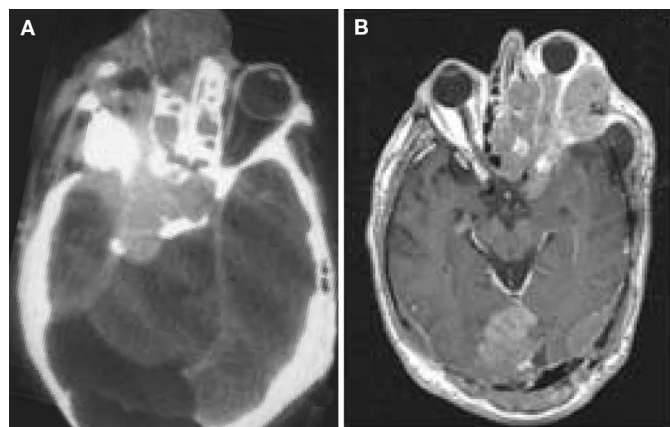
A, axial computed tomographic scan of the brain with contrast showing an anaplastic meningioma causing extensive bony erosion and invasion. B, axial T1-weighted image with contrast showing a large anaplastic meningioma infiltrating the orbit and sinuses, causing severe exophthalmos.
